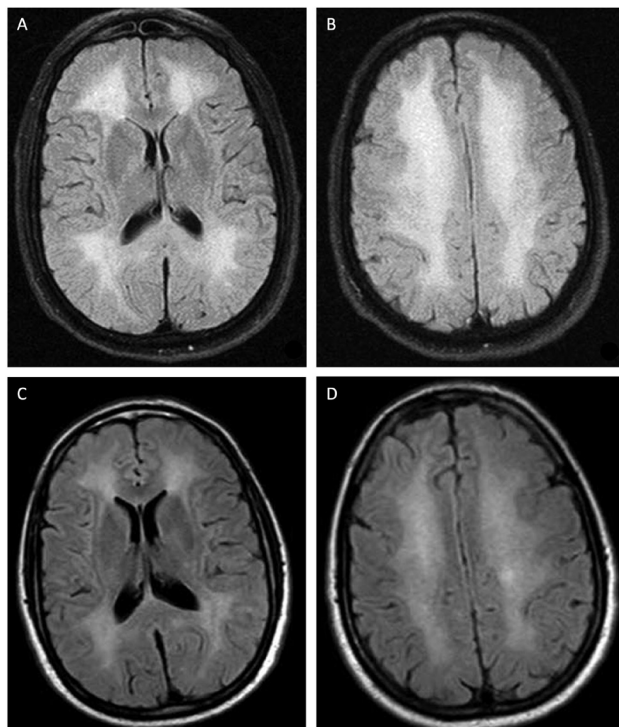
MR scan of brain. Axial FLAIR sequence of a man in his 40s who was a salesman of toluene-containing solvents. Images show diffuse confluent T2w/FLAIR signal hyperintensity indicating widespread white matter involvement at presentation (A) and (B). Some improvement was seen 6 weeks later, (C) and (D) when he had returned to behavioural and cognitive baseline. From: Qureshi *et al.*⁴¹ Reproduced with permission from Cambridge University Press. FLAIR, fluid-attenuated inversion recovery.
